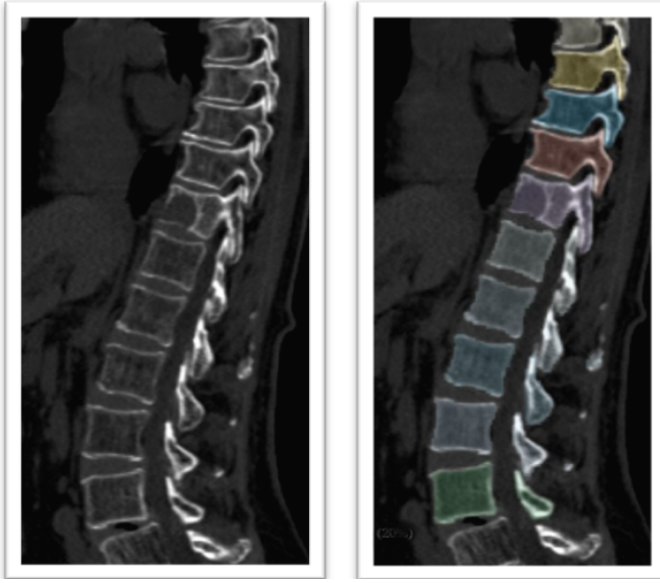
Spine CT Image Segmentation
